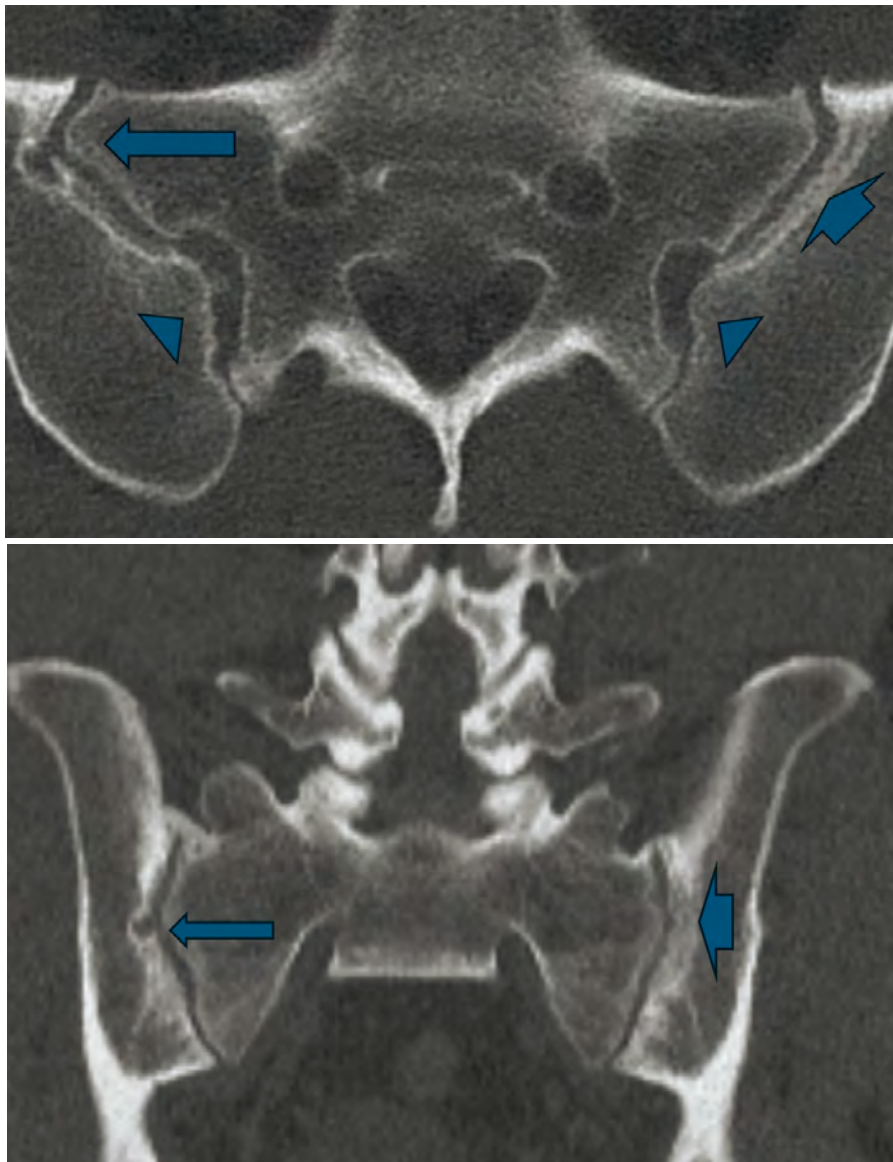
CT scan sacral-lumbar spine axial view (top) and coronal view (bottom). Long arrow: Erosion with punched-out appearance; Short arrow: Irregularity along sacroiliac joint; Arrowhead: Sclerosis.
